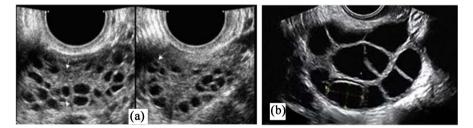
(a) Pelvic ultrasound by vaginal route on the 3rd day of menstruation with more than 16 follicles per ovary; (b) Polyfollicular ovary on the 8th day of stimulation: High risk of ovarian hyperstimulation.
